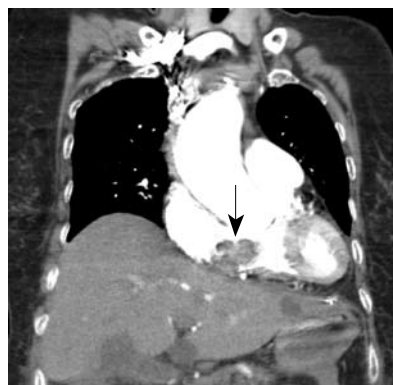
Computed tomography scan revealed that the mass (arrow) was located in the right atrium, obstructing the tricuspid valve opening.
